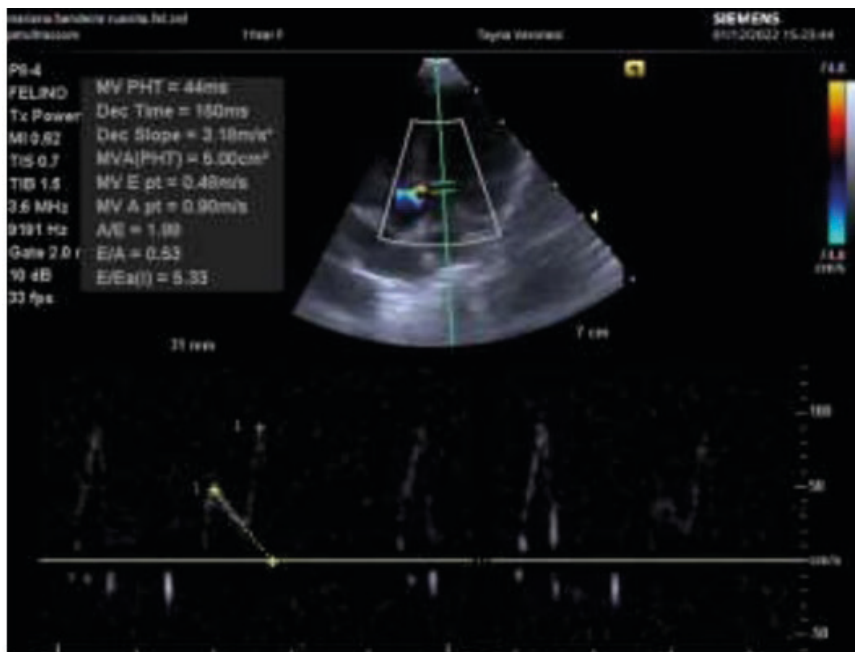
Pulsed Doppler echocardiography, caudal left parasternal window, apical four-chamber view, for evaluation of the transmitral flow, demonstrating an abnormal relaxation pattern, with the E wave velocity lower than the A wave.
